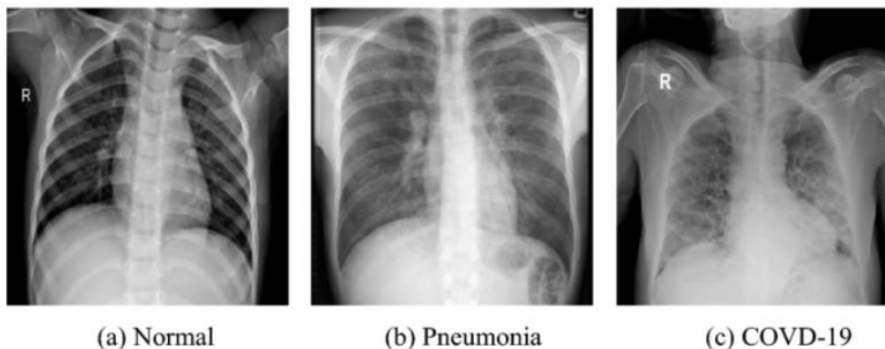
Chest X-Ray images of affected lungs*
